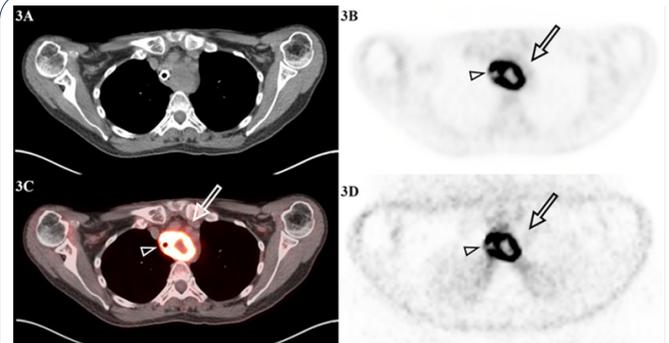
Patient 2 Axial FDG PET/CT images. Axial CT (3A), attenuation-corrected PET (3B), fused PET/CT (3C) and non-attenuation corrected PET (3D) images demonstrate contiguous intensely FDG avid masses in the superior mediastinum that encase the trachea (open arrowhead) and esophagus (open arrow).
